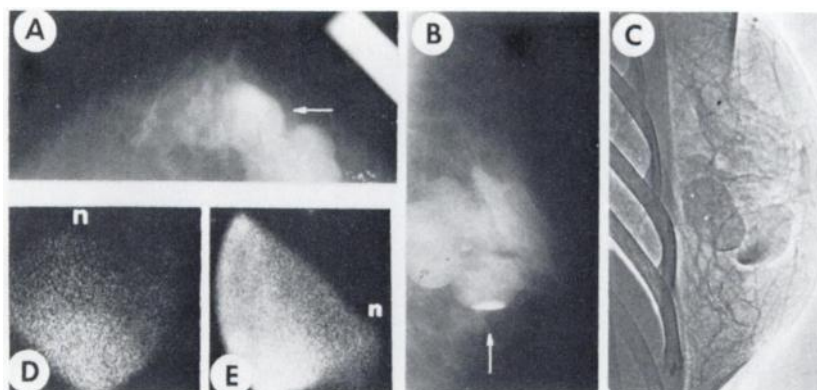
Craniocaudal mammography (A), mediolateral mammography (B), and mediolateral xeroradiography (C) demonstrate fibrocystic disease with "milk of calcium" in one large cyst. Craniocaudal (D), and lateral (E) $^{99m}\text{TcO}_4$ breast scintigraphy is negative. Fibrocystic disease was confirmed at surgery.
